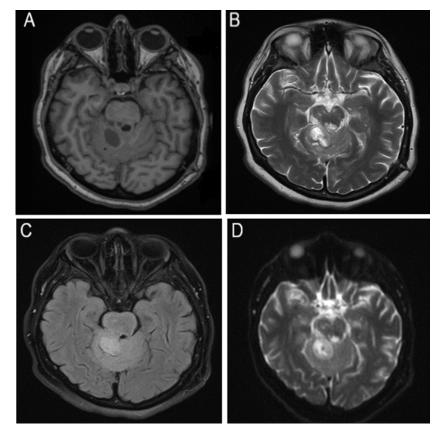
MRI axial sequences showing the most prominent cystic lesion located at the culmen. A. T1-weighted sequence showing a hypointense cystic lesion. B. T2-weighted imaging sequence showing hypointense cystic lesion with hyperintense content. C. FLAIR sequence showing isointense-walled cystic lesion with hyperintense content. D. Diffusion-weighted image showing restriction to diffusion. Note the presence of multiple lesions with similar characteristics.
